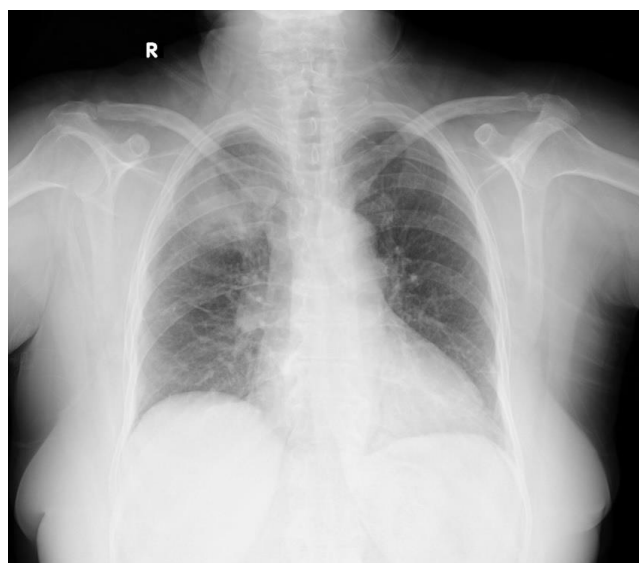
Non-homogenous density increase observed in the right upper zone on PA chest X-ray at the time of hospital admission
